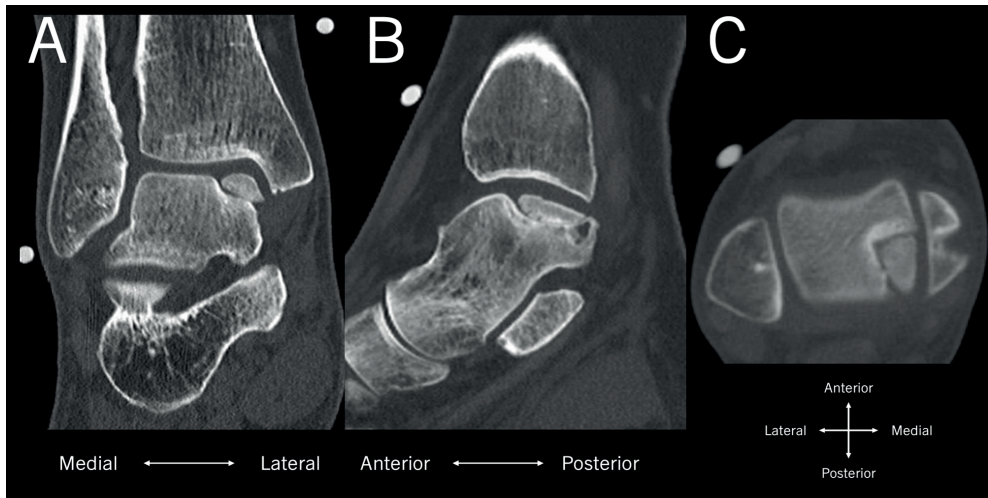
CT-scan of the ankle joint showing an osteochondral fragment on the posteromedial talus, as depicted from the coronal view (A), sagittal view (B), and axial view (C).
